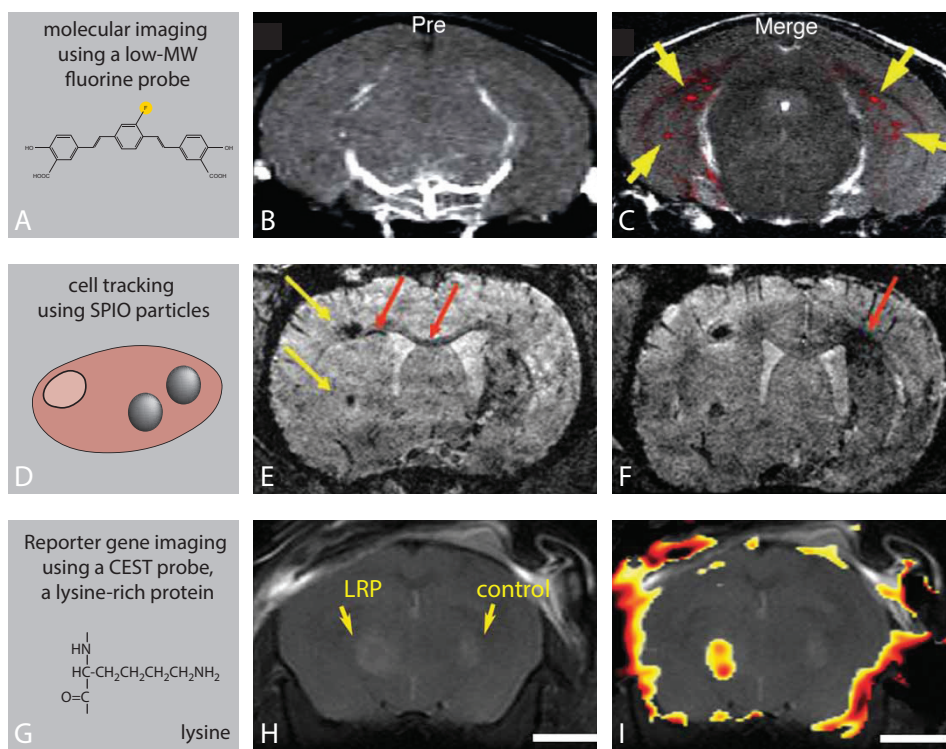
In vivo* examples of molecular neuroimaging using MRI
